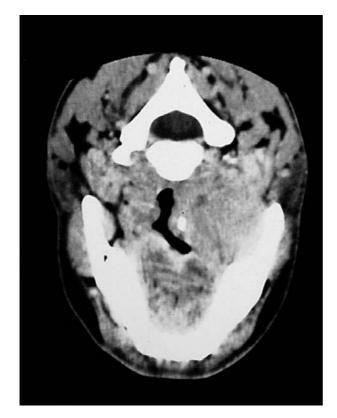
Case 1: Axial CT scan of left parapharyngeal mass.
